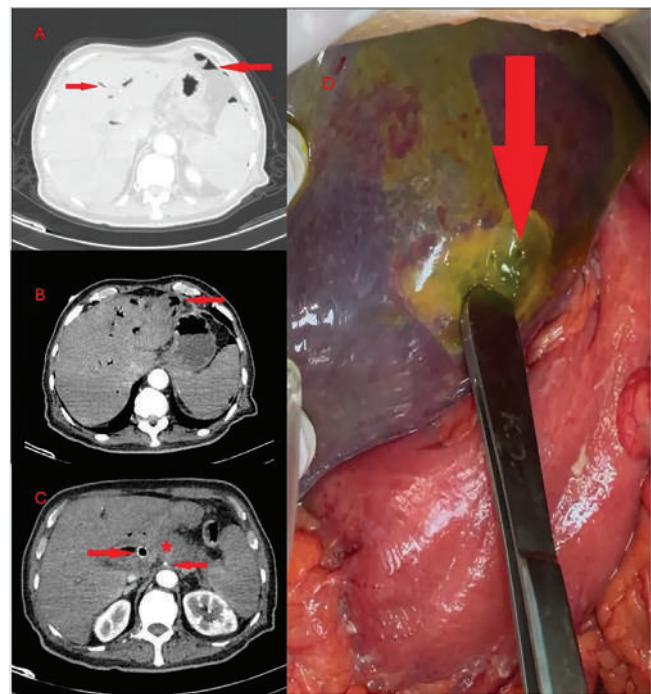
Preoperative radiological evaluation and Intraoperative findings. (A) Abdominal CT scan shows subdiaphragmatic free air (left arrow) and intrahepatic pneumobilia (right arrow). (B) Suspected rupture area at the level of Segment 2 of the liver (left arrow). (C) Mass at the head of the pancreas (star) and metallic biliary stent (right arrow). (D) Intraoperative image: Glisson's capsule opened, cavity debridement performed, and U-suture repair.
